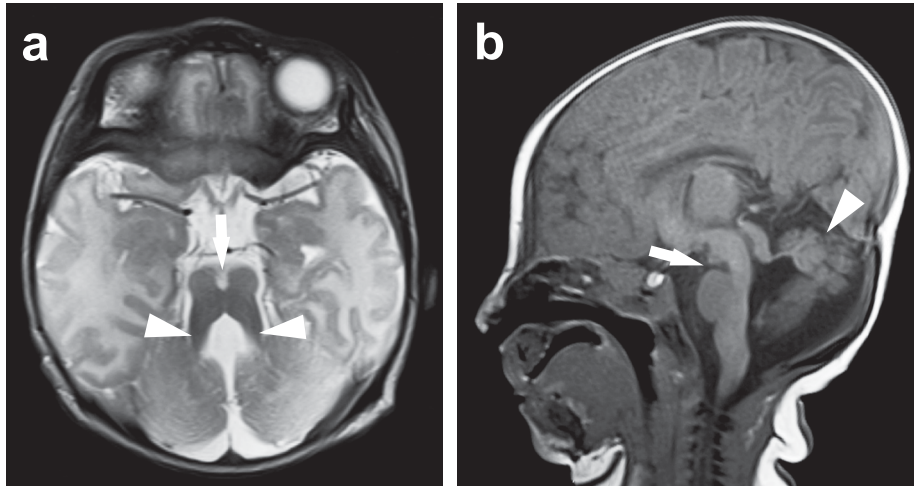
Clinical features of JBTS. a) axial T2-weighted (MRI) scan in a 5-year-old girl showing typical brain anomalies of JBTS, including a deepened interpeduncular fossa (arrow) and elongated superior cerebellar peduncles (arrowheads) that comprise the pathognomonic “molar tooth sign”, as well as cerebellar vermis hypoplasia; b) a sagittal T1-weighted MRI scan showing the deepened interpeduncular fossa (arrow) and cerebellar vermis hypoplasia (arrowhead). The cerebellar hemispheres and brainstem are also hypoplastic. Images are used by kind permission of Dr Daniel Doherty (Seattle Children's Hospital, University of Washington, USA).
